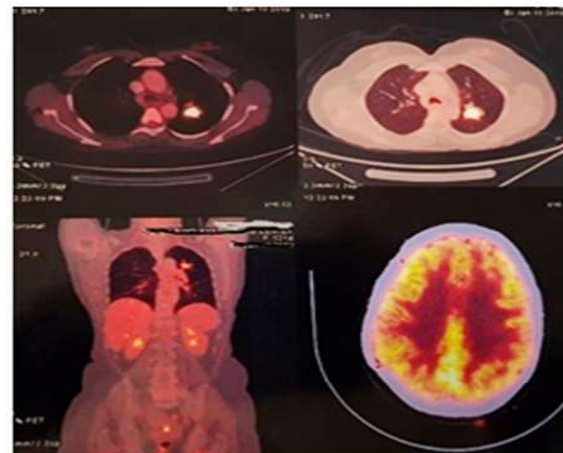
PET CT showing left lung lesion
